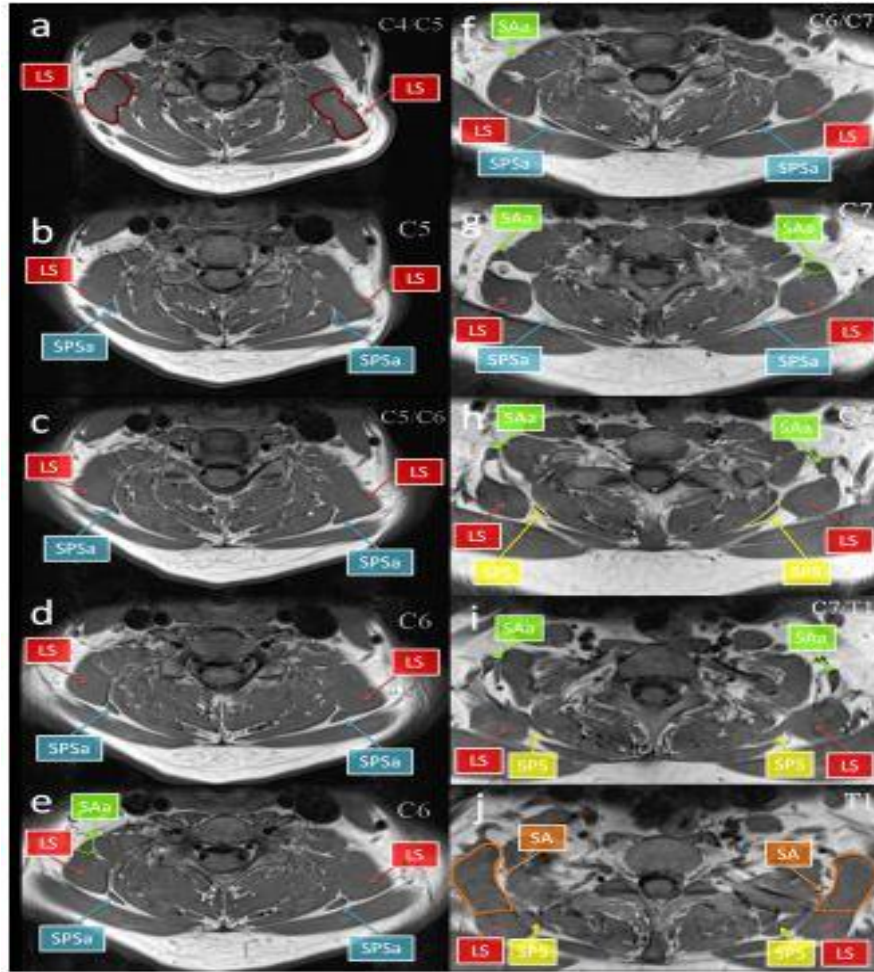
T1-weighted MRIs from superior (a) to inferior (j) obtained from a single subject (subject 16) with bilateral accessory attachments (SPSa) to serratus posterior superior (SPS) and bilateral accessory attachments (SAa) to serratus anterior (SA) (Adapted from Au et al., 2016).
